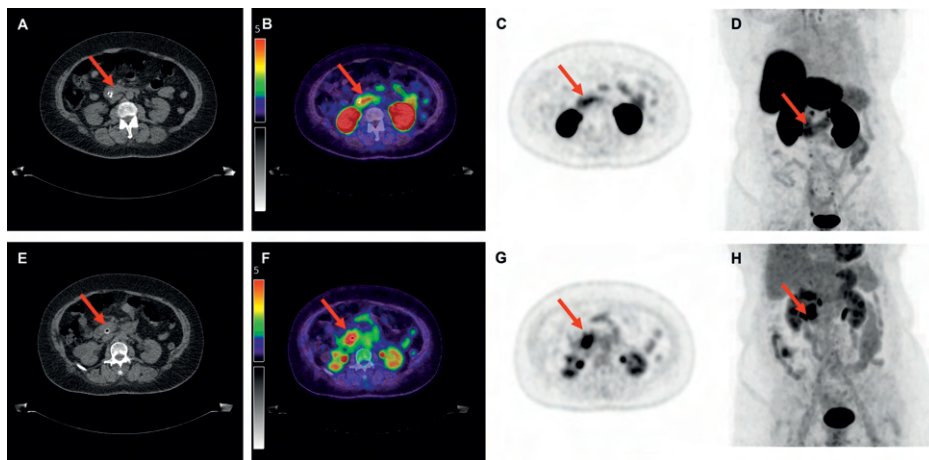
Overview of imaging modalities of a patient with pT2N2M0 pancreatic ductal adenocarcinoma (patient 10). The arrows indicate (upper row) a lesion with moderate to intense $[^{18}\text{F}]\text{DCFPyL}$ expression with an SUV_{max} of 5.1 and (bottom row) a lesion with $[^{18}\text{F}]\text{FDG}$ uptake with an SUV_{max} of 10.1. From left to right: low-dose CT (A,E), fused PET/CT (B,F), PET (C,G), and the maximal intensity projection (MIP, (D,H)). Image scale SUV 0-5.
